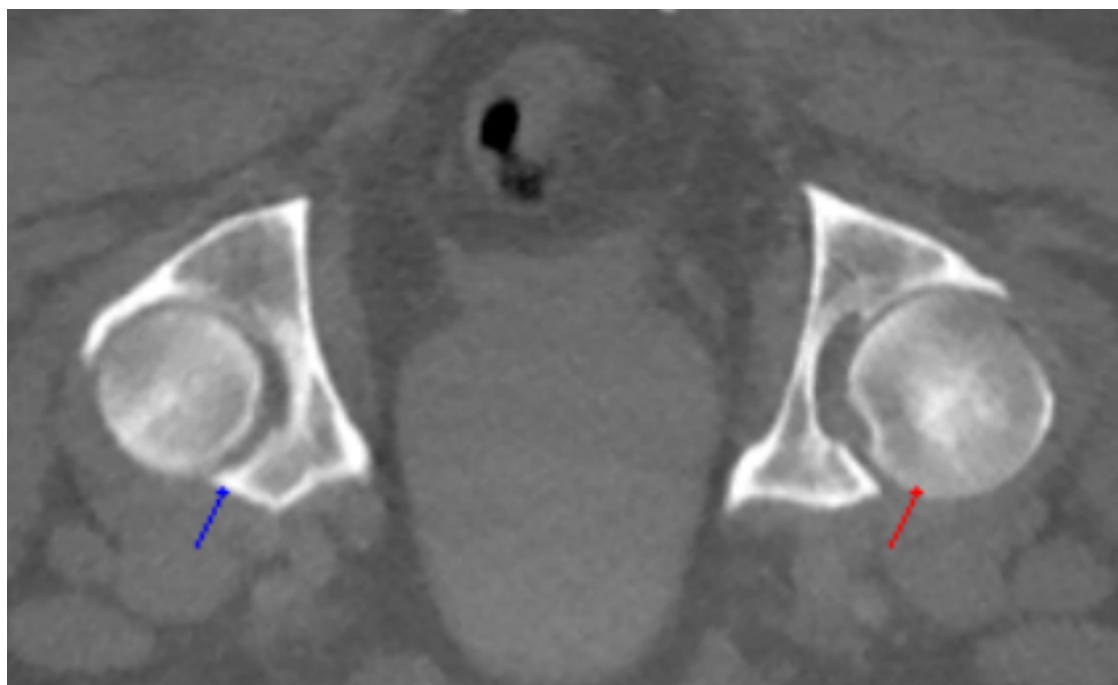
An example of a poor symmetrical point match. This will cause a decrease in the overall accuracy of the algorithm, since clearly the wrong points are being compared. The underlying CT data is from the Addenbrooke's Hospital CT Data Collection.
